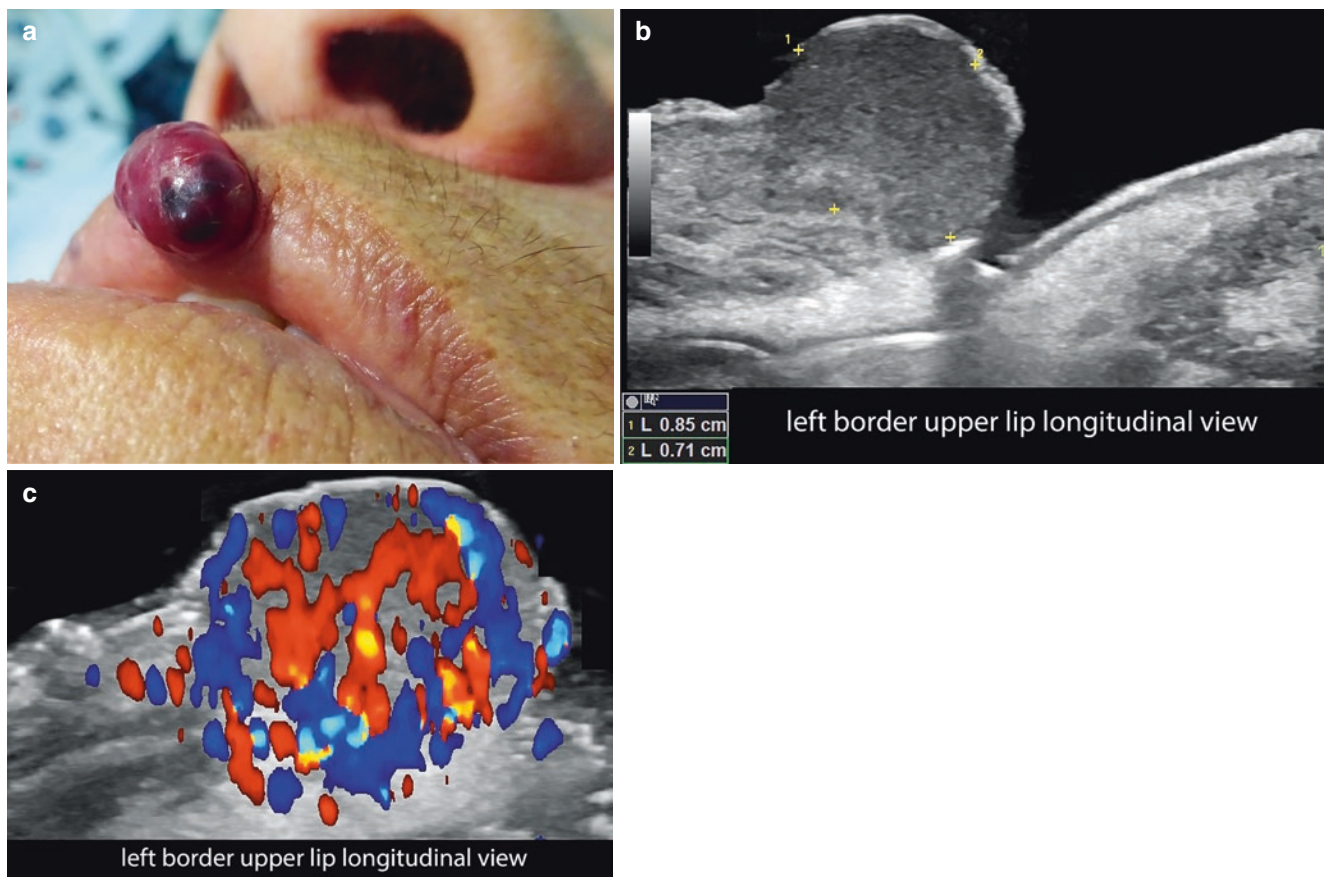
Telangiectatic granuloma. (a) Clinical image of the lesion in the upper lip. (b and c) Greyscale and color Doppler ultrasound (longitudinal views; left border of the upper lip) demonstrates 8.5-mm
